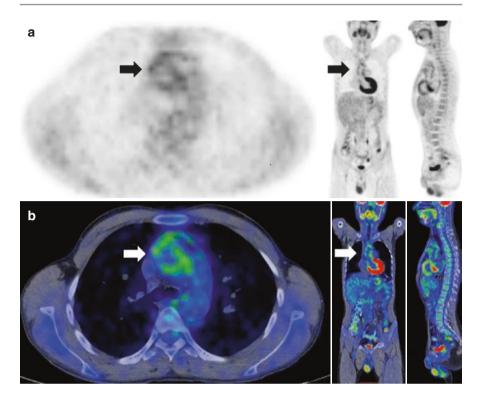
Axial, coronal and sagittal positron emission tomography (PET) (a) and PET/CT fusion (b) images of the same patient shows fluorine-18 fluorodeoxyglucose (FDG) uptake at the level of the ascending aorta and the aortic arch (arrows) consistent with activated disease
